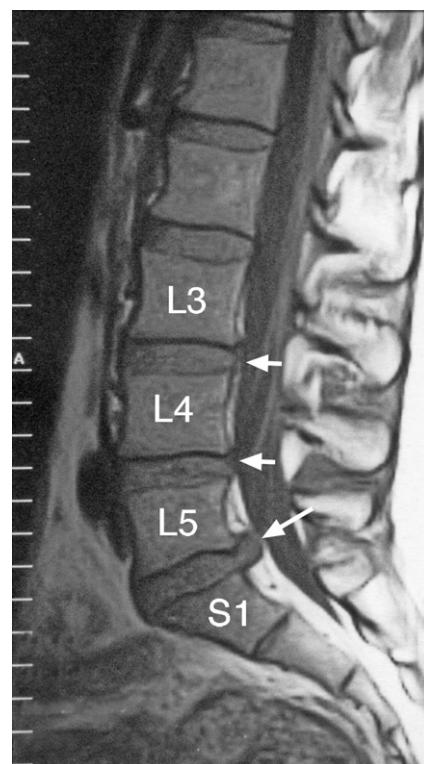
Lumbosacral spine MRI sagittal T1-weighted image showing the (i) L3-4 disc level moderate sized central disc bulge contacting and impressing the dural tube (short white arrow), (ii) L4-5 level shallow central disc bulge contacting and impressing the dural tube (short white arrow), and (iii) L5-S1 early narrowing and a large focal disc protrusion (large white arrow).
